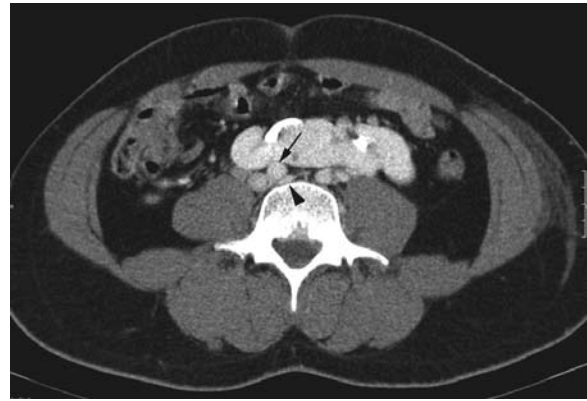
Contrast enhanced CT of the abdomen showed left crossed fused renal ectopia, which may aggravate the compression of right common iliac artery (arrow) on left common iliac vein (arrowhead).
